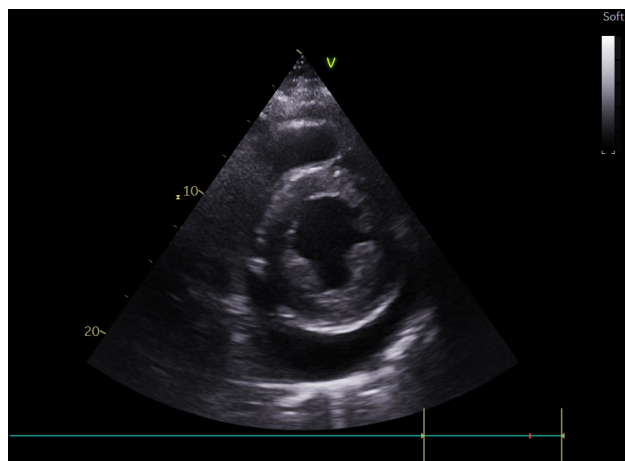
Transthoracic cardiac ultrasound with circumferential fibrinous pericardial effusion (parasternal short axis view).
